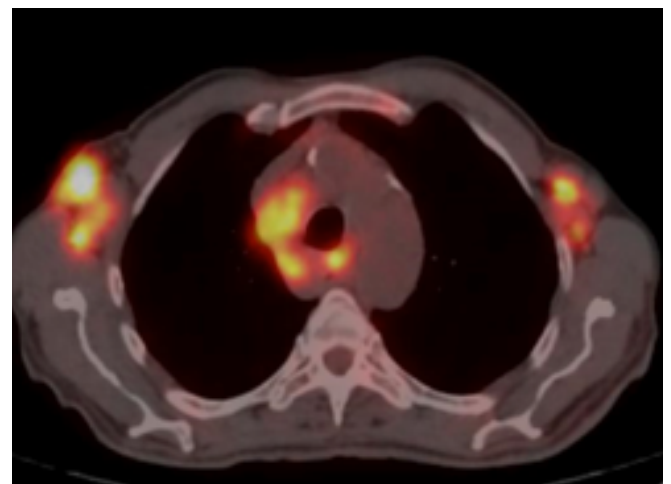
PET-CT image of MLAP patient (Symmetrical axillary involvement in a NHL patient on PET-CT fusion imaging).
